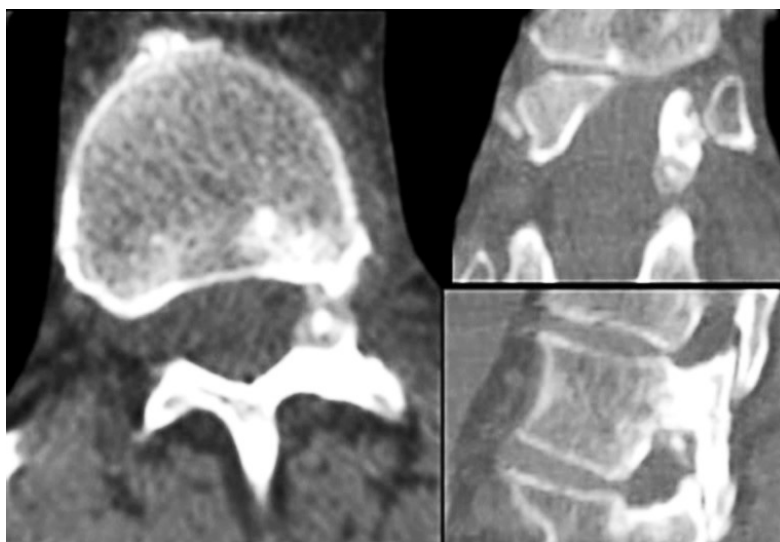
Thin slices CT-scan. Axial, coronal and sagittal images passing through the foramen. A small, ossified core, surrounded by partially calcified tissue, is located at the inferior edge of the left pedicle of 11th thoracic vertebra, close to the nerve root. The bony trabeculae of the pedicle are thickened.
